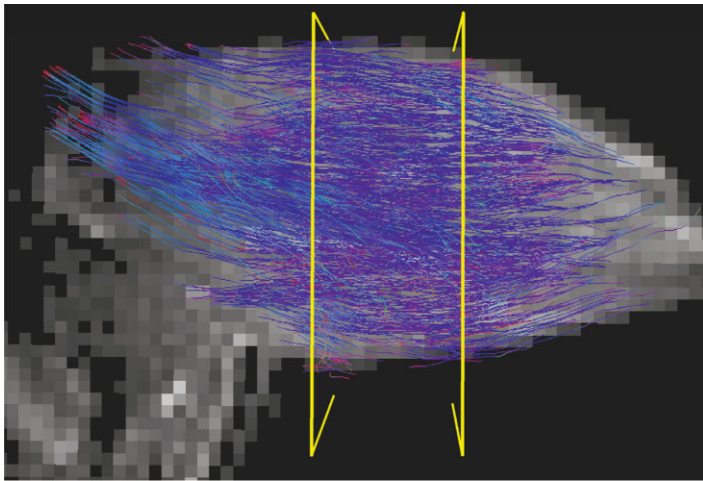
Fiber tracking in the same data set as in Fig. 1. Fiber tracking was started from the two slices indicated by the yellow lines. The 3D fibers are projected on a 2D MRI slice.
